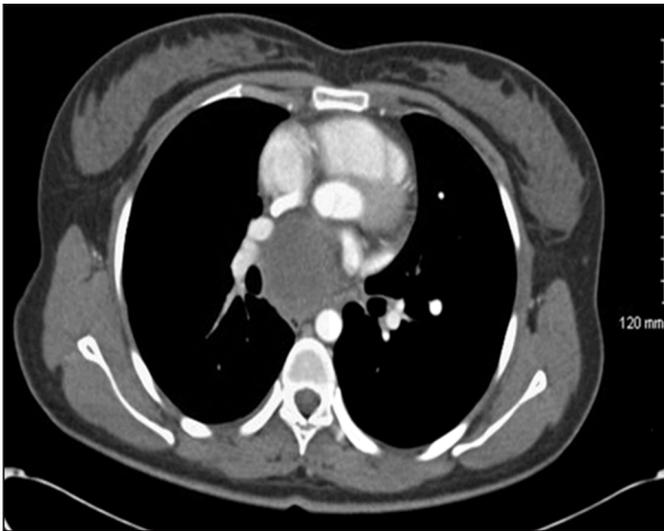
Chest CT showing a 45 x 38 x 46 mm elliptical, well-margined mass measuring about 34-35 Hounsfield units in the middle mediastinum just below the carina.
